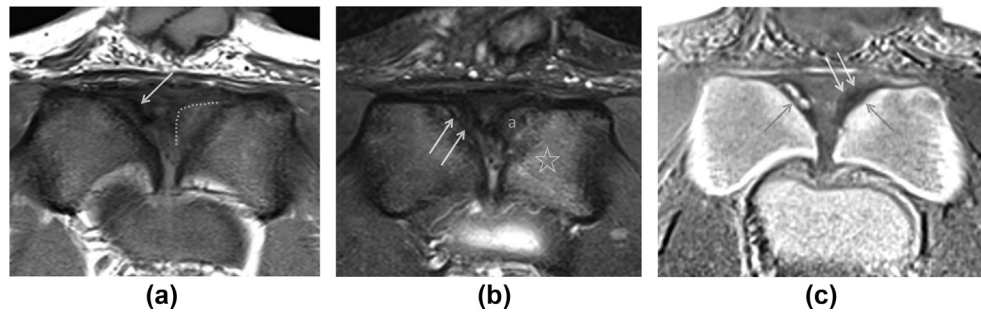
A 20-year-old elite AFL player with left groin pain. (a) Axial T1 MRI showing superior left pubic apophysitis at the adductor longus attachment. The apophysis is swollen (dashed line) and diffusely increased in signal compared to the right. Note the intermediate signal appearance of the normal right apophysis deep to the developing secondary ossification centre (arrow). The left subchondral bone is ill-defined when compared to the right. Note the right pubic marrow signal is iso-intense to the apophysis, due to the presence of red marrow. (b) Axial T2-FS MRI at the same level as Fig 3a, showing moderate left pubic body marrow oedema (star), in addition to the swollen high-T2 signal left pubic apophysis (a) outlined in Fig 1a. Normal intermediate signal right pubic apophysis (arrow) is hypo-intense to the left pubic apophysitis. (c) Axial inverted VIBE MRI more clearly distinguishes the superior pubic apophyses from ossified pubic body bone. There is delayed maturation of the left apophysis (arrows) superiorly, which is more clearly swollen and higher in signal compared to the right, compatible with left pubic apophysitis; a smaller secondary ossification centre was present just below this image. The subapophyseal bone on the left is more subtly ill-defined compared to the right compatible with early apophysiolysis (grey arrows). The developing right secondary ossification centre is clearly resolved. Note the low signal appearance of the normal right ventral apophysis, which is iso-intense to the thin dorsal hyaline cartilage.
